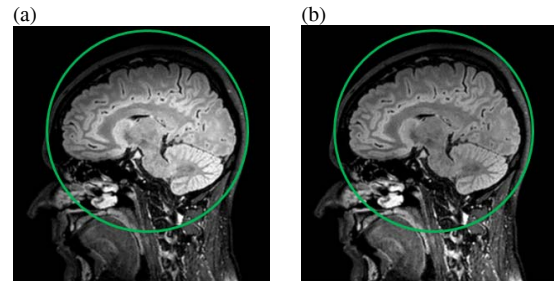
Brain FLAIR inhomogeneity correction. (a) uncorrected; (b) correction shown at central slice. Green markers highlight the inhomogeneous areas of interest.
